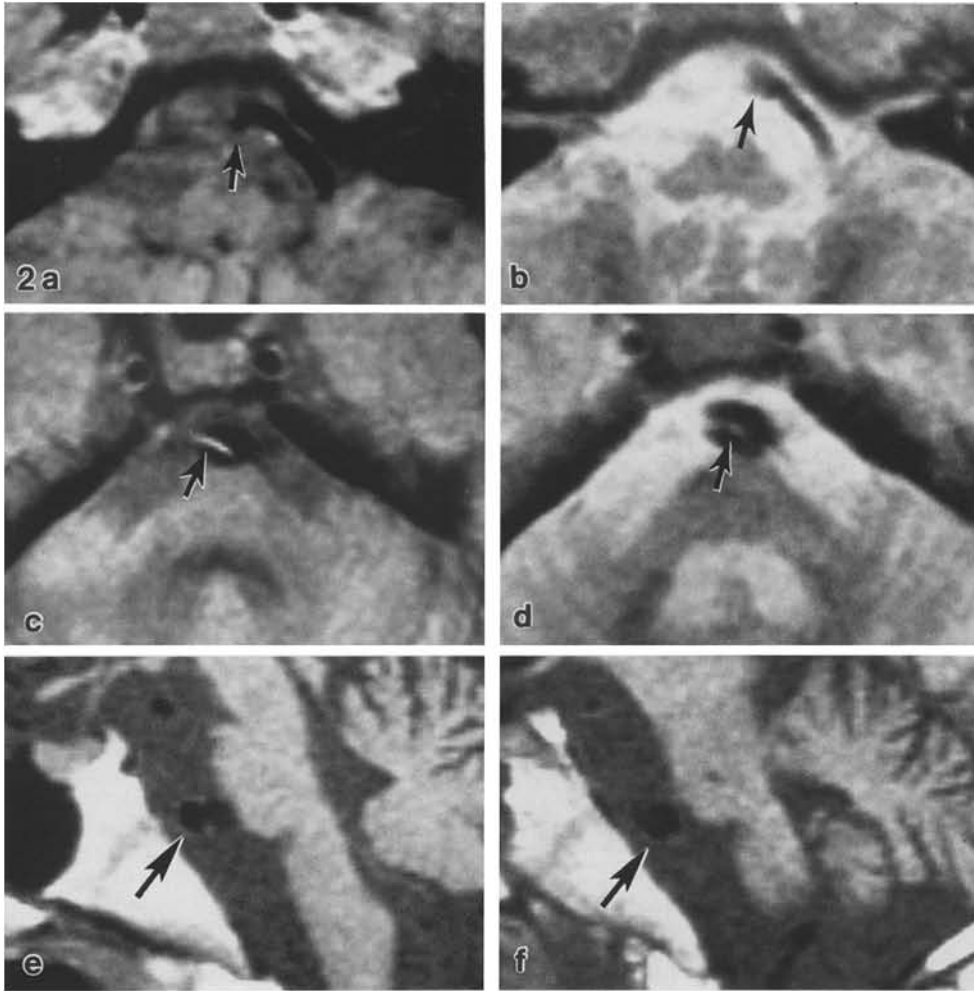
a-f. Case 1. PD-weighted (a) and T2-weighted (b) axial images showing a terminal dilatation of the left vertebral artery, like a cudgel-shape, as a signal-void area (arrows). A linear structure, corresponding to the linear defect demonstrated in the vertebral angiogram (Fig. 1), is depicted inside the dilated vessel on PD-weighted (c) and T2-weighted (d) axial images of the vertebro-basilar junction level (arrows). Consecutive mid-sagittal T1-weighted images (e, f) demonstrate a double lumen (arrows)
